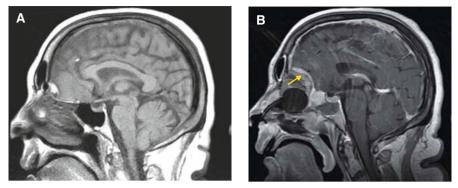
Transcribriform approach for olfactory groove meningioma. Preoperative (A) and postoperative (B) brain MRI showing the complete resection of an olfactory groove meningioma with transcribriform EEA. This 59-year-old woman presented with neurocognitive decline. The nasal Foley is seen in the second image supporting the nasoseptal flap (arrow) reconstruction
